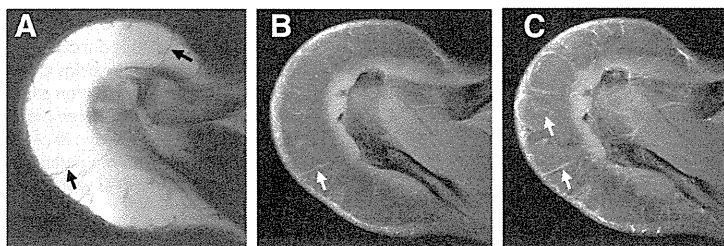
A 40-year-old male patient with ALT measuring 15 cm in diameter. Axial T1-weighted image (A) and T1-weighted fat saturation image (B) clearly demonstrated thick septa (arrows). T1-weighted fat saturation after gadolinium administration demonstrated enhancement of these septa (C). This case obtained 5 points using the ALT score.
